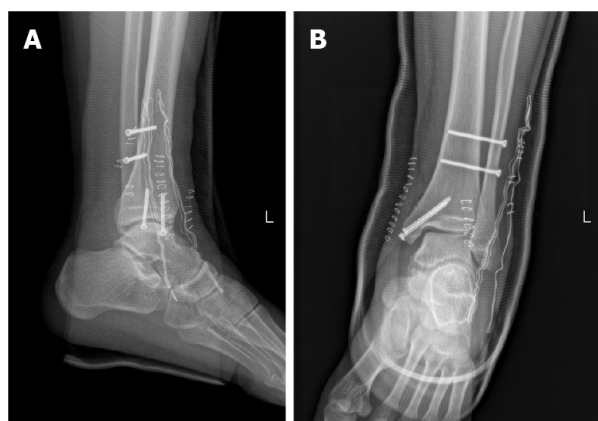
Ankle radiographs of anteroposterior and lateral views after secondary surgery. A: Anteroposterior; B: Lateral.
